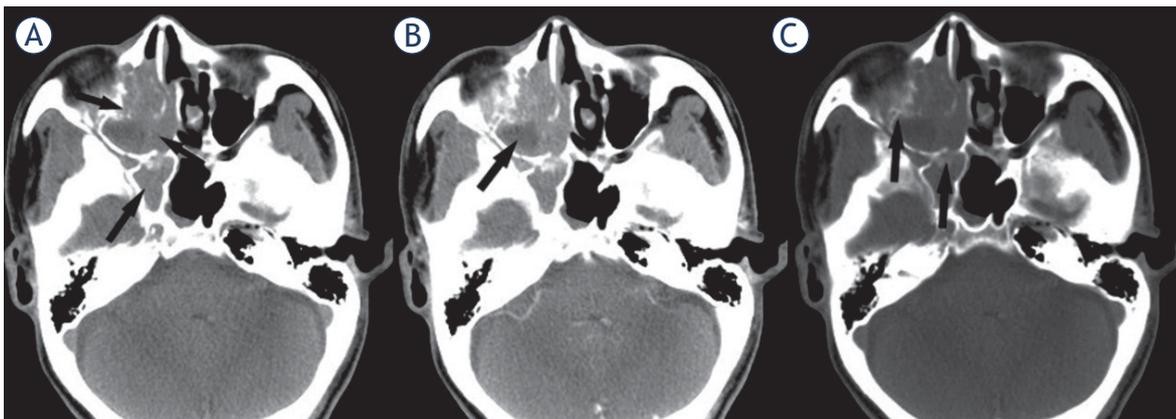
A 54-year-old man with PTCL in the sinonasal cavity. (A) Axial non-contrast CT image shows an ill-defined, irregular mass with inhomogeneous density in the right nasal cavity, maxillary and sphenoid sinus (black arrows). (B) Contrast-enhanced CT image shows the tumor with heterogeneously moderate enhancement. Intratumoral necrosis is seen in the mass (black arrow). (C) Bony destruction is detected on non-contrast CT image. The tumor relapsed 11 months after therapy.
